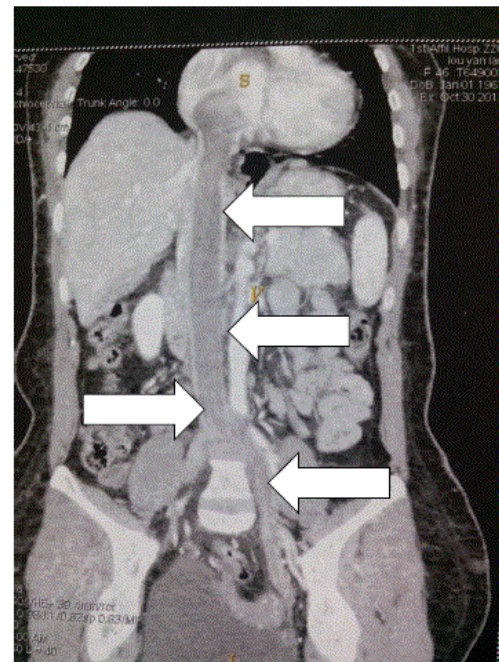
Preoperative computed tomography scan reveals intracaval filling defects extending between the left iliac vein and the right atrium.
